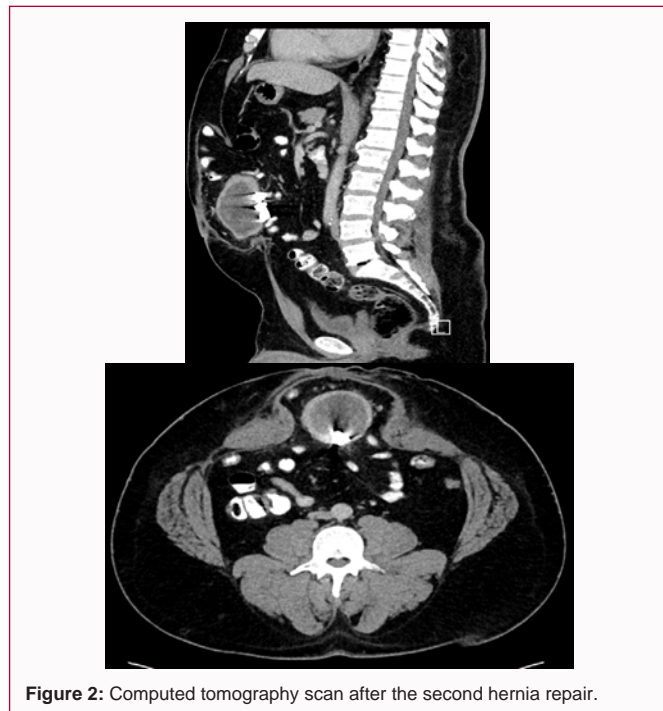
Computed tomography scan after the second hernia repair.
